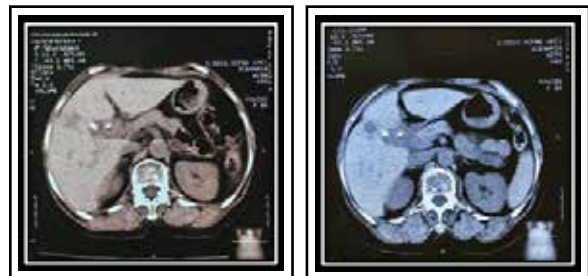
(A) CT scan in March 2024; (B) CT scan in September 2024
